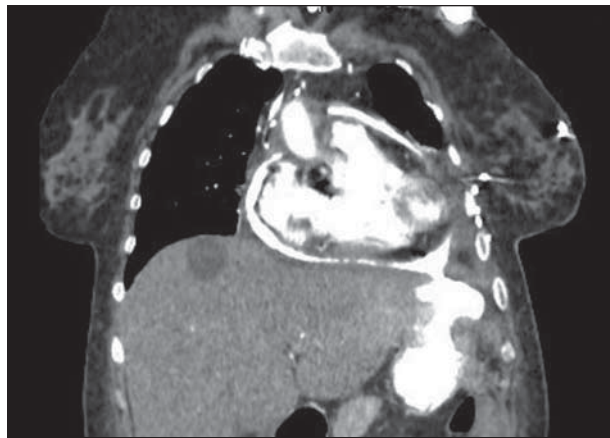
Computed tomographic scan of the chest and abdomen of a 63-year-old woman after contrast material was orally administered.
